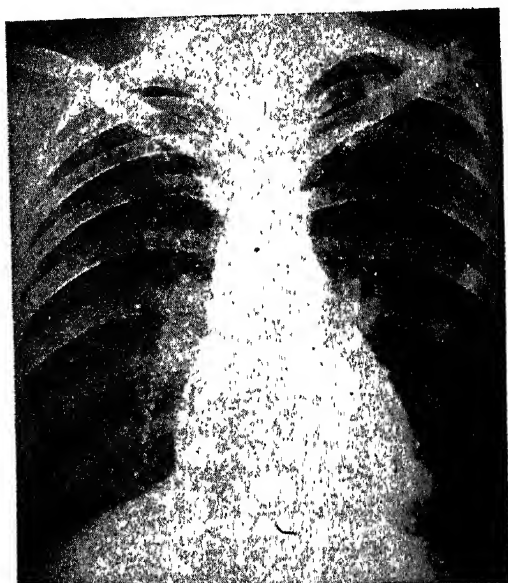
Twenty-nine-year-old male with long-standing mitral stenosis. Died later of congestive heart failure. Note the widespread calcification with predominating distribution in the lower lung fields. (A. Grishman and I. J. Kane: *Am. J. Roentgenol.* 53: 575 (June) 1945.)
